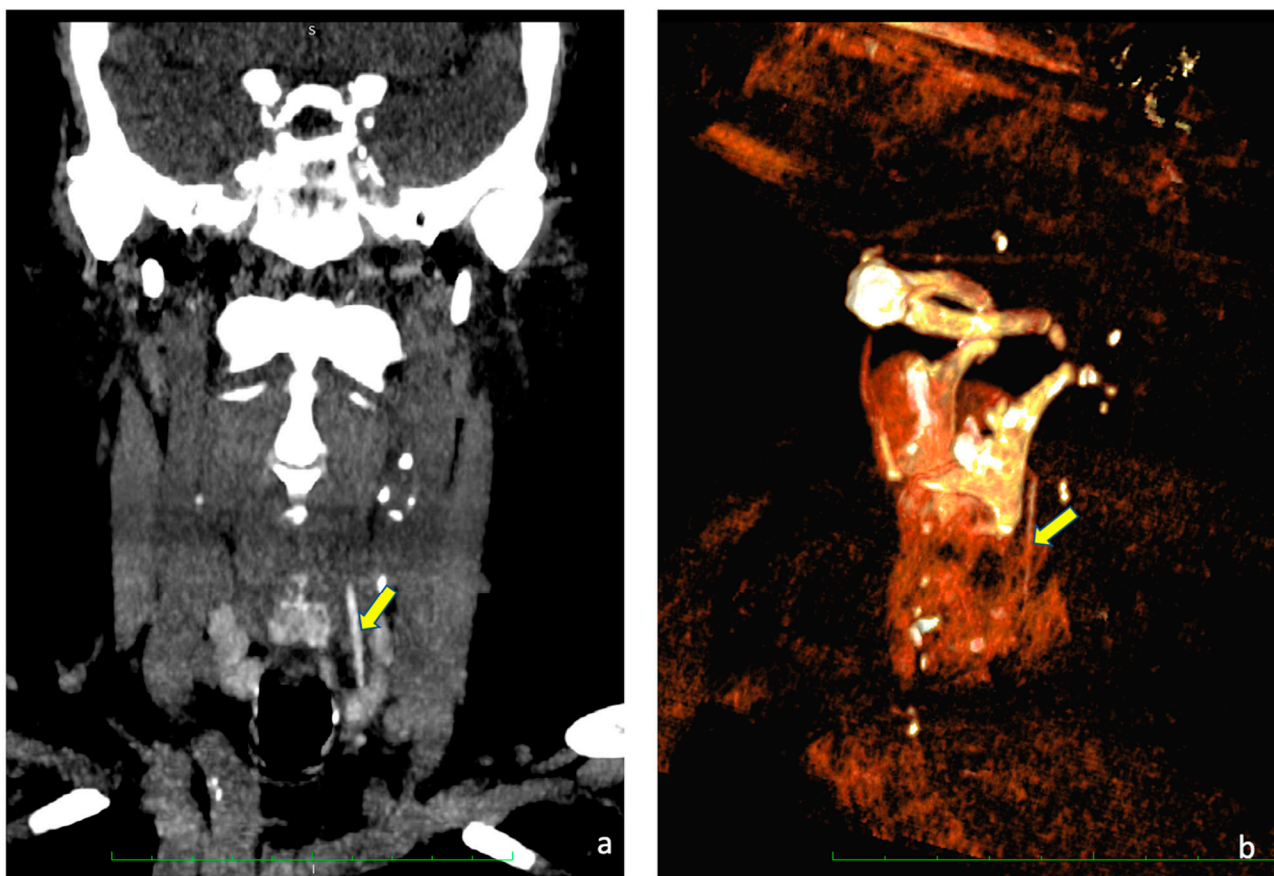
(a) CT scan of the neck, coronal view. (b) 3D reconstruction. In both pictures, the yellow arrow points toward the toothpick.
